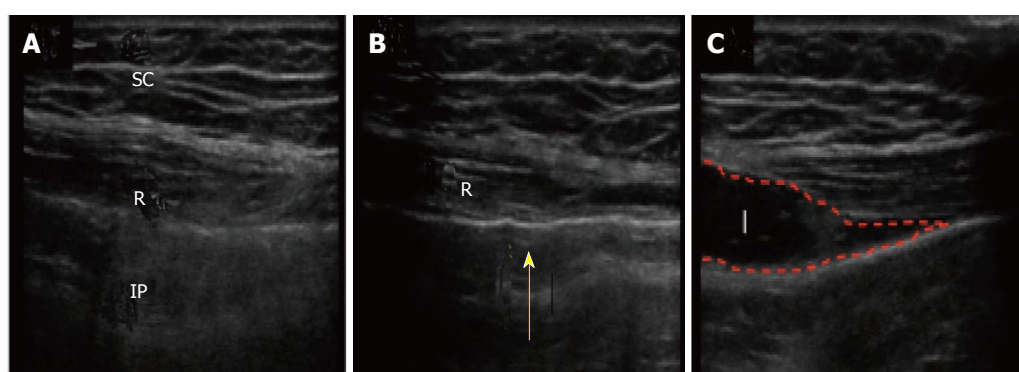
Ultrasound images. A: The muscle layers; B: The Peti-needle™ positioned below the peritoneum, the notch was made by the needle tip (yellow arrow) before the needle was inserted via the peritoneum; C: Local analgesic was then administered into the correct layer. R: Rectus muscle; IP: Intraperitoneal space; SC: Subcutaneous tissue; I: Injectate.
